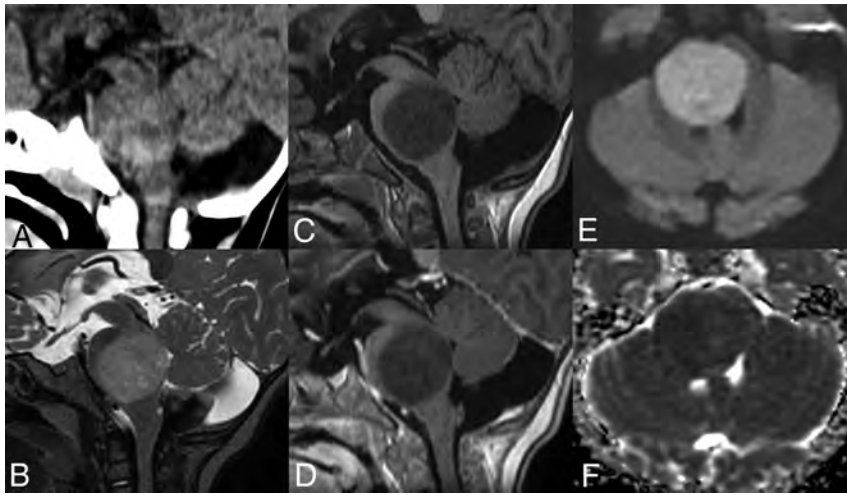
Brain imaging of patient 4. Sagittal plane image on CT (A) shows a pontine isodense mass. The tumor displays hypointensity on the T1-weighted image (C), hyperintensity on the T2-weighted image (B), and no enhancement after contrast media injection (D). Diffusion signal is high (E) with low ADC (F).
